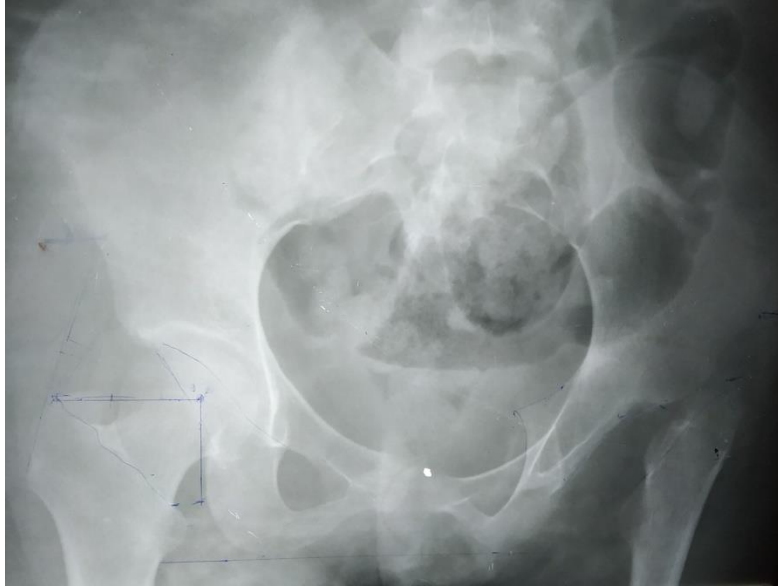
The x-ray of the pelvis after the greater trochanter was drawn at the level of articular surface of the acetabulum.
